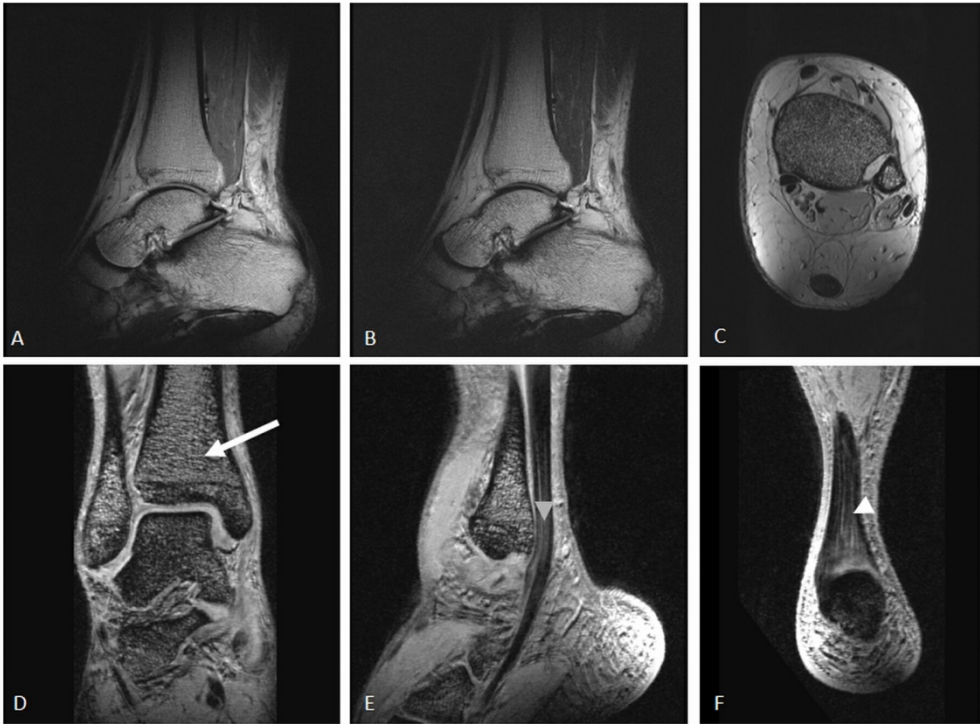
Static images of the human ankle: (A-B) PD/T2-weighted TSE through the ankle joint; (C) axial slice through the distal tibia from a 3D DESS showing a diffuse hypertrophy of the subcutaneous fat without disturbing susceptibility artifacts, (D-F) reformatted 3D FLASH images showing the trabecular structure of the bones (arrow) as well as the fibers of the peroneal (grey arrowhead) and the Achilles tendon (white arrowhead) with high contrast.
